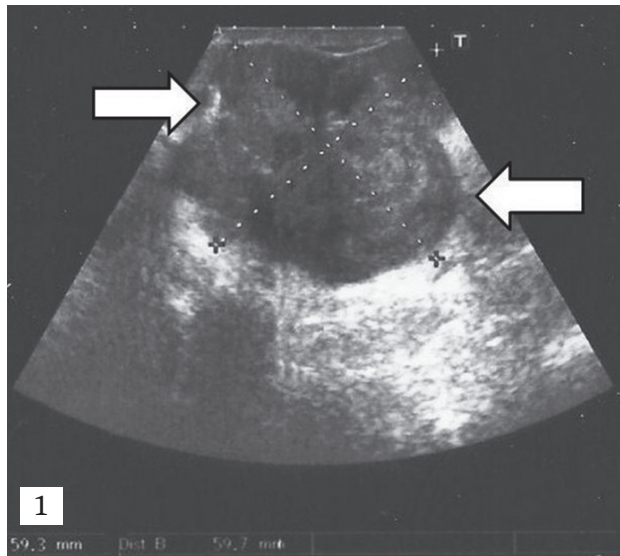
B-mode ultrasound image of the scrotum (oblique plane). Lobulated left paratesticular mass with mixed echogenicity pattern, measuring 6 cm in diameter (between arrows).
